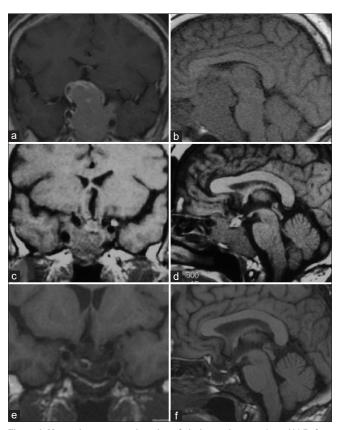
Magnetic resonance imaging of pituitary adenoma. (a and b) Before the first stage of surgical treatment (removal by transcranial approach). A giant pituitary adenoma of endo-supra-latero-infrasellar localization is visualized. (c and d) 3 months after tumor removal via transcranial approach and cabergoline treatment before the second stage of surgical treatment (removal with transsphenoidal approach). The remainder of the tumor in endo-latero-infrasellar localization is visualized. (e and f) 10 years after the removal of the tumor during therapy with cabergoline. Regression of the tumor size and the empty sella
